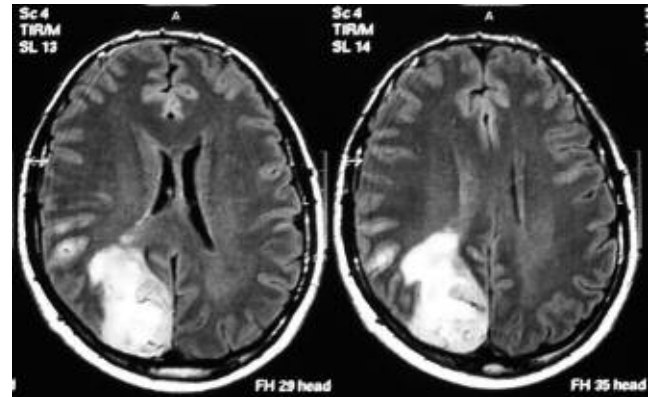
T1-weighted axial MRI FLAIR sequences showing the tumor lesion before the surgery.
